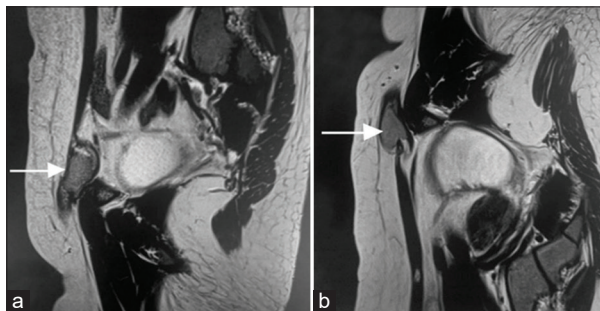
(a and b) sagittal T2-weighted imaging showing the right and left ovaries, respectively, in the inguinal canal
